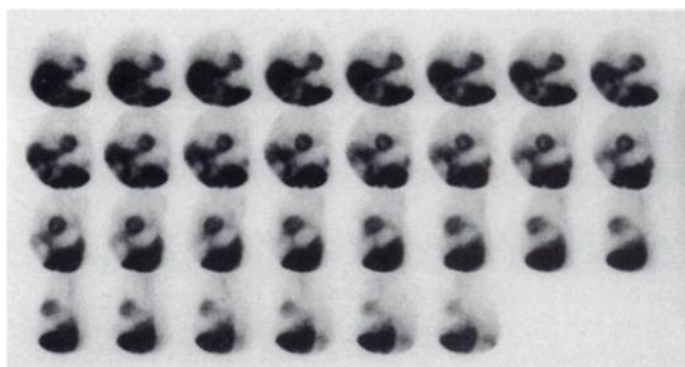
Raw data of rest myocardial SPECT image 20 min after an intravenous dose of 20 mCi of $^{99\text{m}}\text{Tc}$ -tetrofosmin. The patient was allowed to have his daily meal 1 hr before injection. Filled stomach appears as a photopenic area between myocardium and intestines in the frames.
